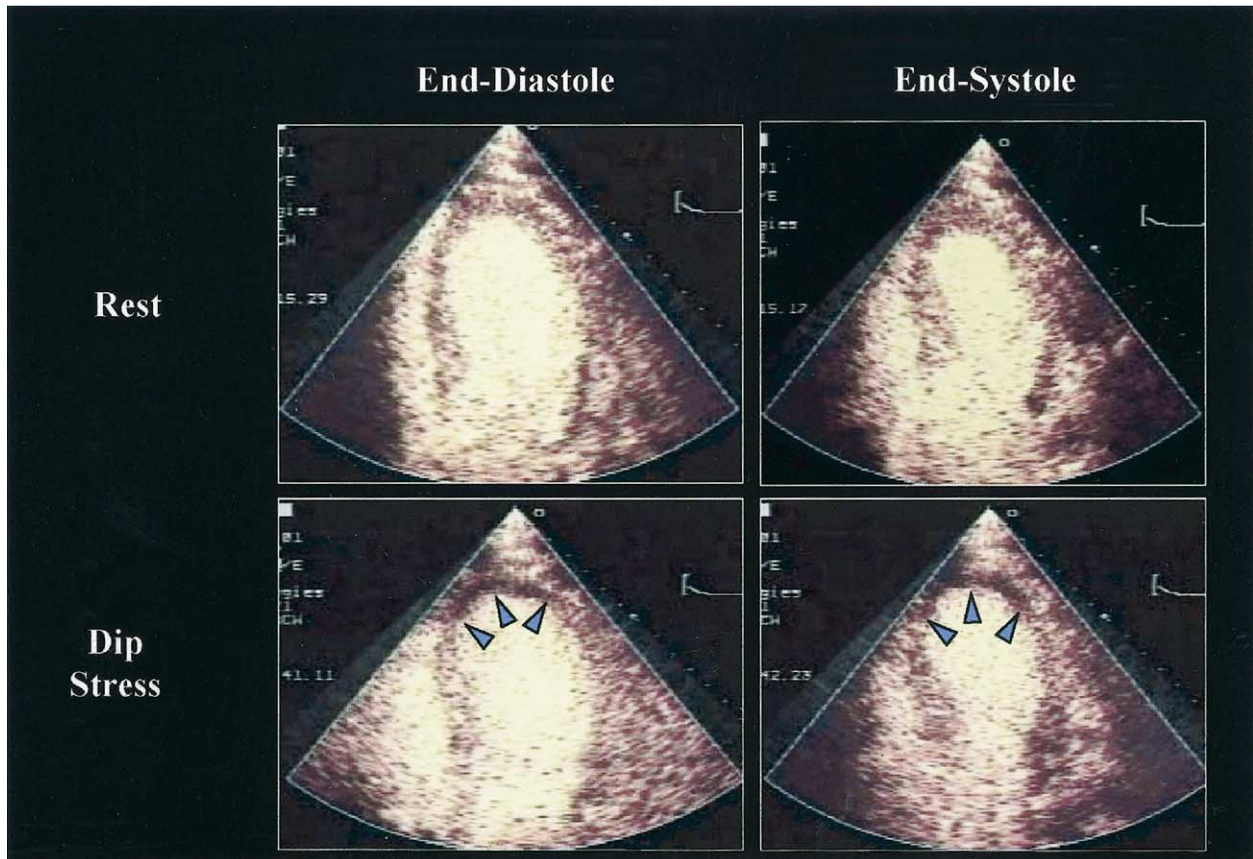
Dipyridamole (Dip) stress contrast echocardiography using real-time perfusion imaging at a low mechanical index, showing images at end diastole and end systole in a patient with significant stenosis of the left anterior descending coronary artery. Note the perfusion defect that developed in the apex (highlighted by arrows) and the corresponding wall motion abnormality.
